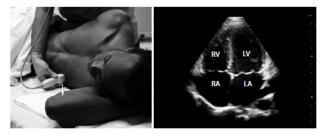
Left: photo position of the probe Right: US image (apical four chamber view) Source: Used with permission from Partners in Health Manual of Ultrasound for Resource Limited Settings
